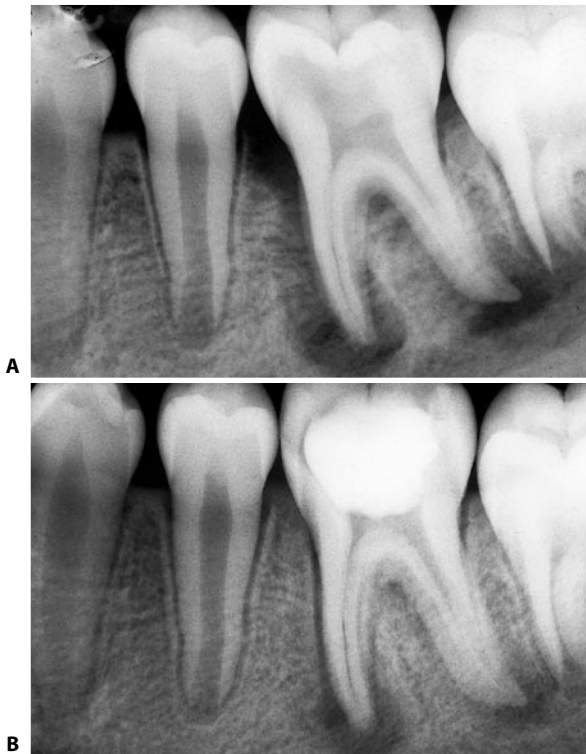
A. Preoperative radiograph of a lower left first molar. B. Radiograph two months later. This period of time elapsed because of neglect on the part of the young patient. The four canals had been cleaned, shaped, and medicated with Cresatin. Note the progression of the healing process, which has proceeded in spite of the fact that the canals had not yet been obturated and thus were completely empty.
